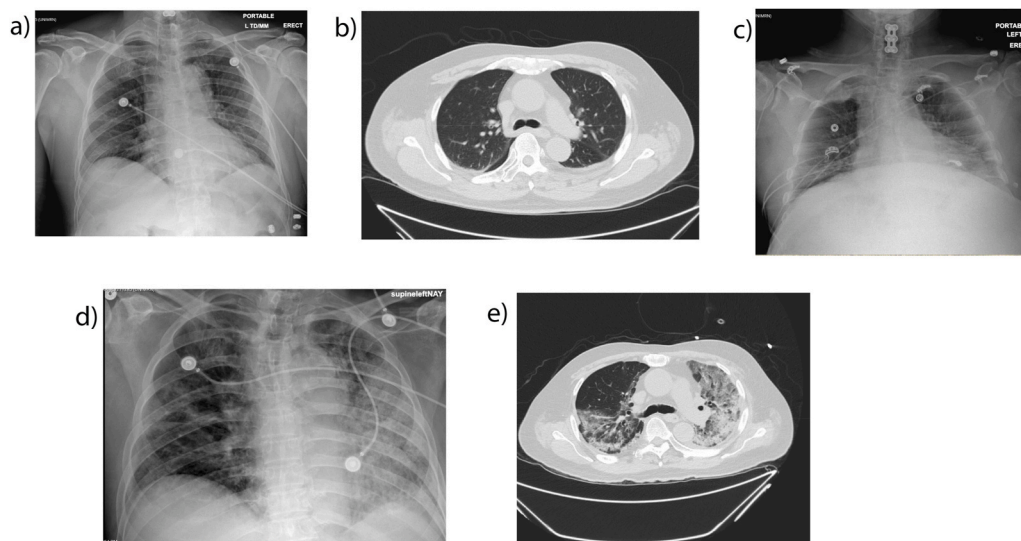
2A & 2B (clockwise from left to right): Admission CXR with bilateral atelectasis. Admission CT chest notable for mild airway inflammation and bilateral trace pleural effusions. Fig. 2C: Discharge CXR is unchanged. Fig. 2D and E and (From left to right): Readmission CXR with diffuse patchy airspace disease throughout the left lung and moderate patchy airspace disease in the right lung markedly progressed. Readmission CT chest with extensive multifocal GGO.
